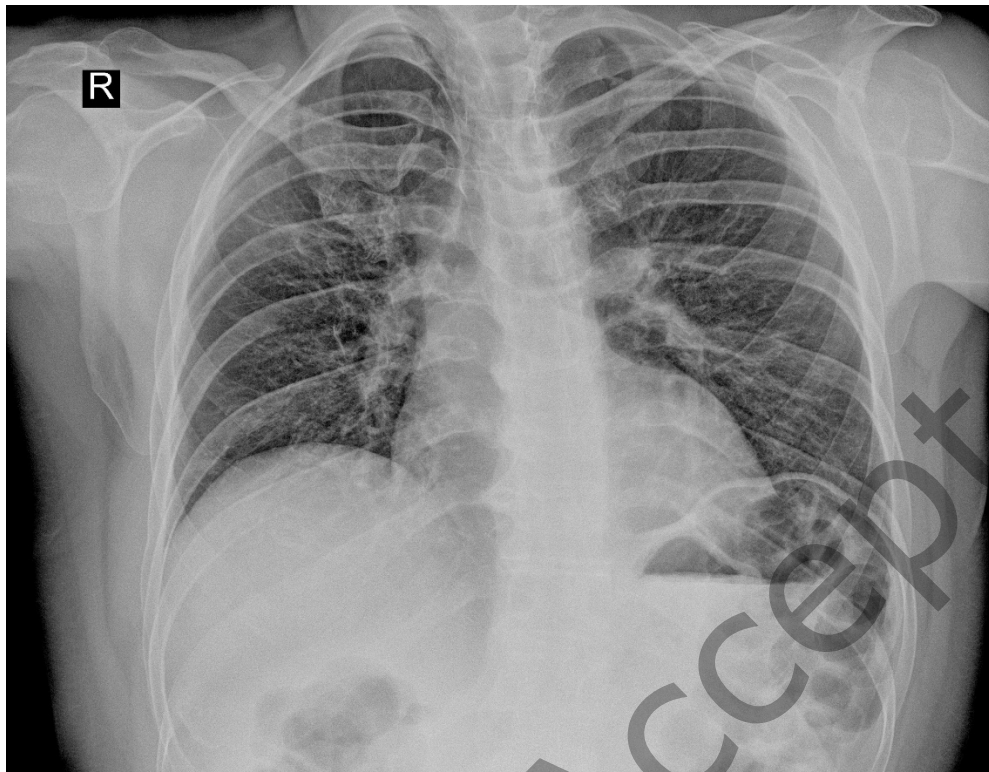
X-ray on the thirteenth day of tocilizumab therapy
